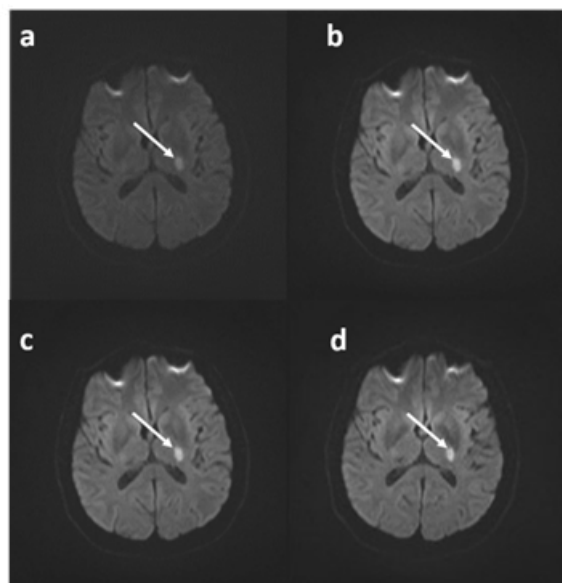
MRI layer Section 2: Acute stroke in the brain has been identified in a 44-year-old lady. Various b -values have been employed to improve the diagnosis of acute stroke: 0-1000 mm^2/s^2 (a) and 100-1000 mm^2/s^2 (b). 200-1000 mm^2/s^2 (c) and 300-1000 mm^2/s^2 (d). The findings indicate that b -values between 0 and 1000 mm^2/s^2 are less sensitive than other values.
